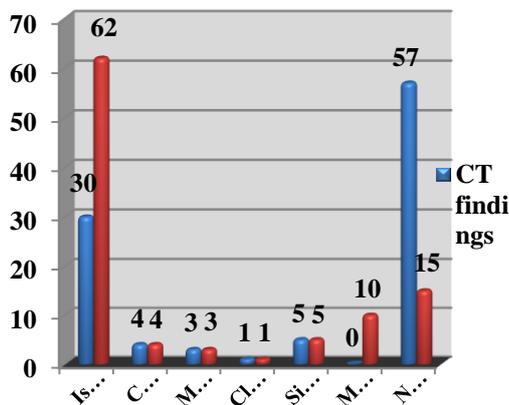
Comparison between CT & MRI findings regarding patients with vertigo according to number of cases.
